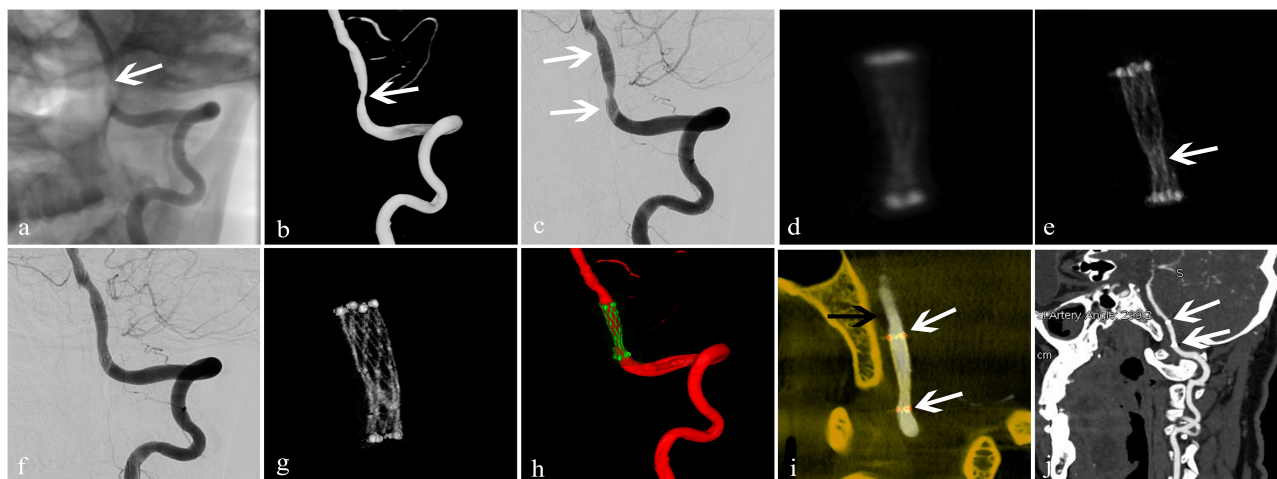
Treatment of an arteriosclerotic stenosis of the V4 segment of the left vertebral artery using the NeuroformTM EZ stent. A 67-year-old man presented with dizziness and instability while standing of 6-day duration. (a,b) 2D and 3D-DSA showed 78% stenosis of the V4 segment of the left vertebral artery (white arrow); (c) dilation using a GatewayTM balloon was done followed by insertion of a Neuroform EZ stent measuring 3.0 mm × 15 mm (white arrow) with 50% residual stenosis; (d) conventional FDCT showed full expansion of the proximal and distal stent markers but poor visualization of the stent itself with an image-quality score of 0; (e) HD-FDCT showed the stent was partially expanded with an image-quality score of 1 (white arrow); (f) angioplasty with a Gateway balloon was undertaken again with a 3.0 mm × 9 mm balloon to treat stent under-expansion. Review by 2D-DSA showed that stenosis was improved significantly (residual stenosis = 11%); (g) after balloon angioplasty, HD-FDCT was done again and confirmed that the stent was fully expanded; (h,i) Dual-volume 3D fusion images showed good apposition of the stent to the vessel wall (stent, white arrow; vessel wall, black arrow); (j) 6-month follow-up CTA showed durable stent patency (white arrow).
